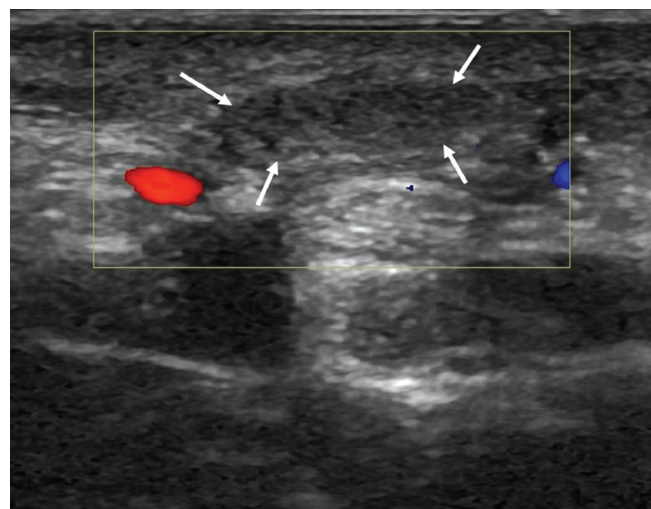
On the color Doppler ultrasonography examination, vascularity is not observed in the hypoechoic nodule (arrows).
